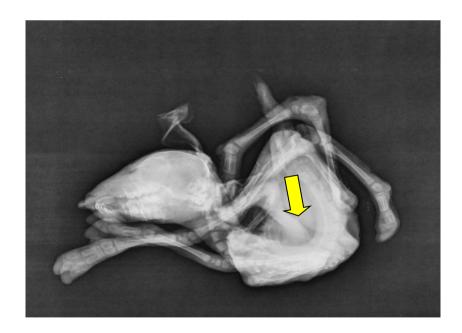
Radiograph of a dead female monstrous *Perosomus horridus* indicating presence of spinal deformity.
